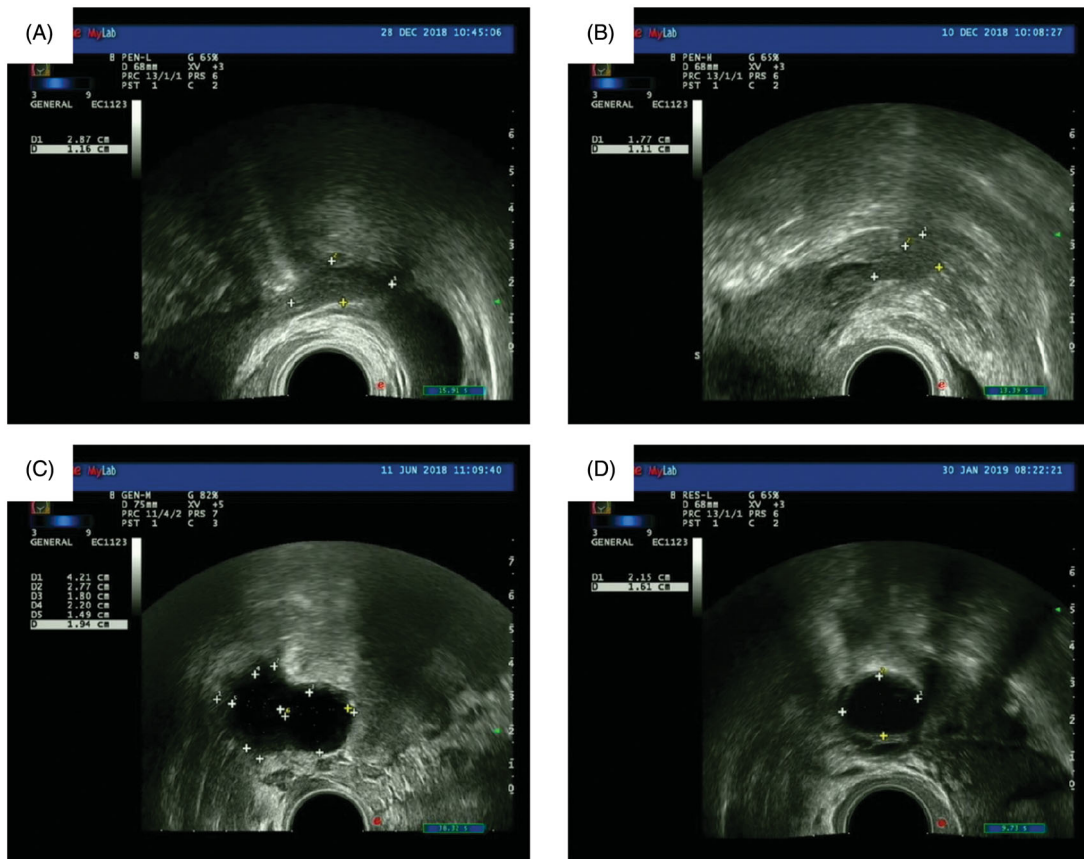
Typical photographs of ovaries and follicles under ultrasound. (A, B) Transplanted ovaries detected by ultrasound after ovarian tissue cryopreservation transplantation (OTCT). (C, D) Follicular development monitored by ultrasound after OTCT.
